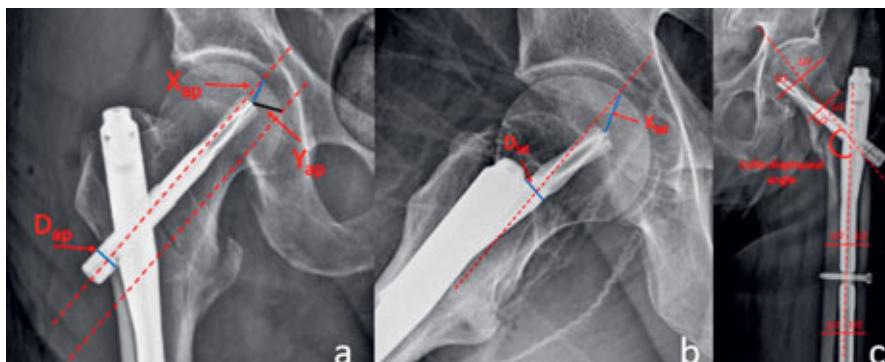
Measurement method of the tip apex distance and calcar referenced tip apex distance on AP radiograph (1a), tip apex distance measurement method on lateral radiograph (1b), measurement method of collo-diaphyseal angle (1c)
